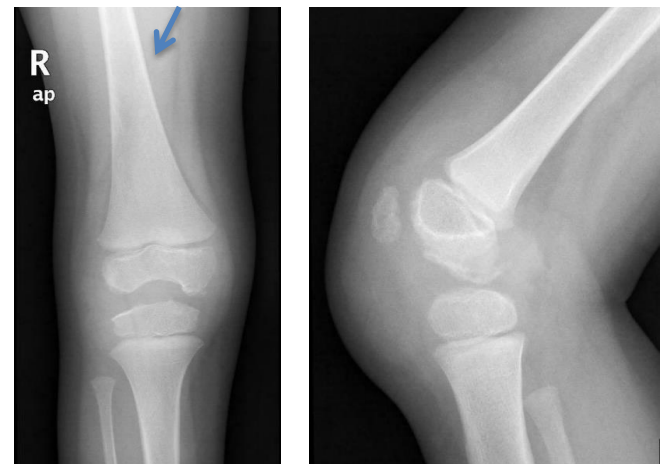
(A) Anteroposterior and (B) lateral radiographic views of the right knee with soft tissue swelling
